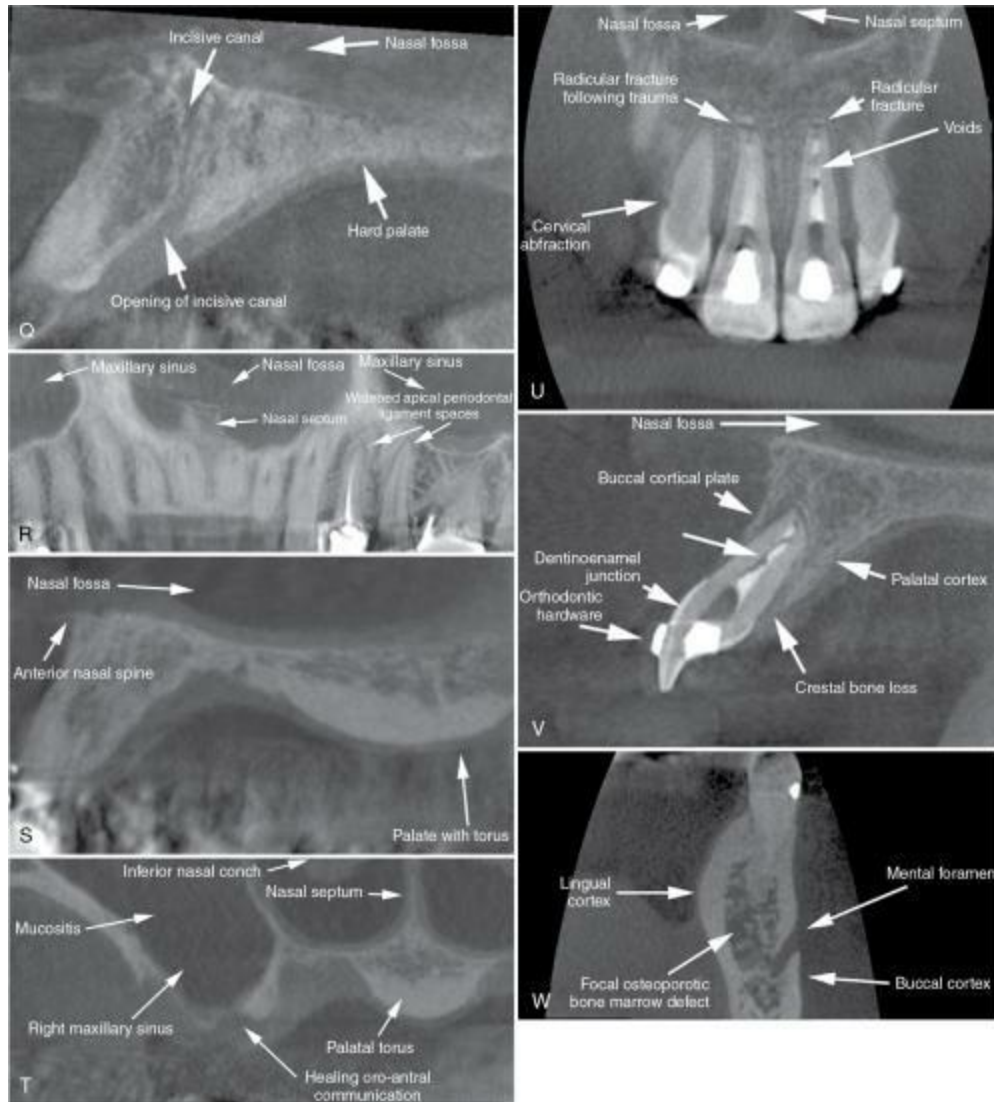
A to W, Anatomic landmarks on CBCT images acquired using CS 9000, CS 9300, and iCAT units.
